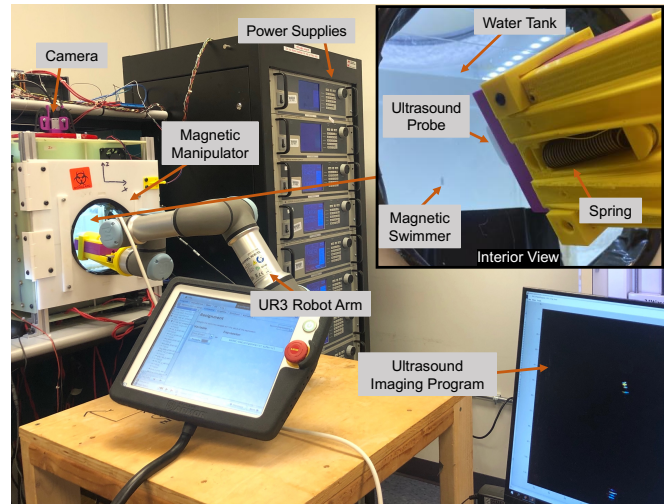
Experiment setup with the robot arm, power supplies, magnetic manipulator, and a computer running ultrasound imaging program. The inset shows an ultrasound probe and a water tank with a swimmer inside.
